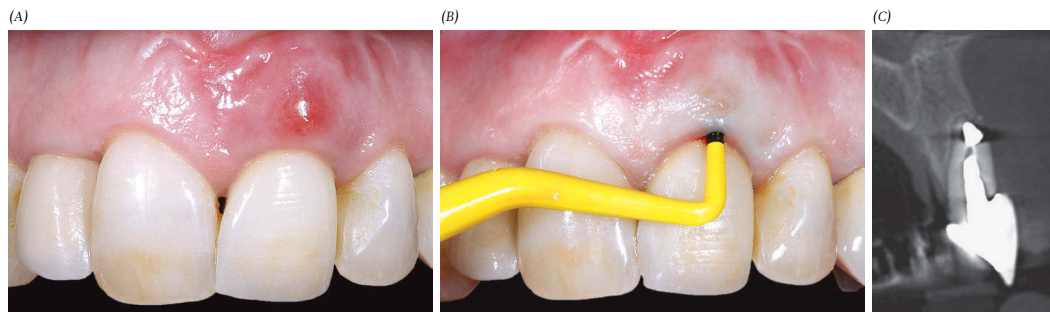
Initial clinical assessment of the compromised tooth #9 with fistula (A, B). The absence of the buccal bone wall is visible on the CBCT image (C).
